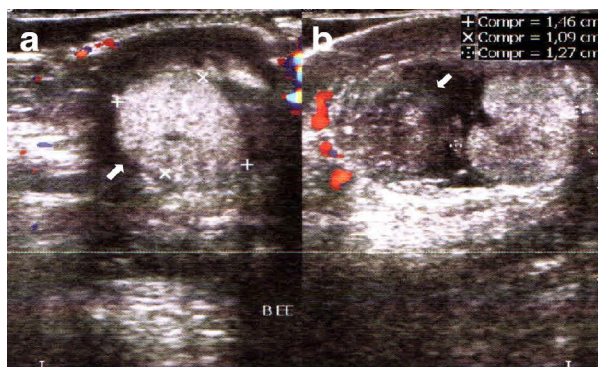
Ultrasonography scans with doppler in the scrotum and left testicle. a - it reveals a preserved testicle volume with a diffused increase of the echogenicity and the absence of flux in its interior. b - a multilobed heterogeneous structure in the topography of the upper third of the scrotum. (BEE = Left Scrotum).
